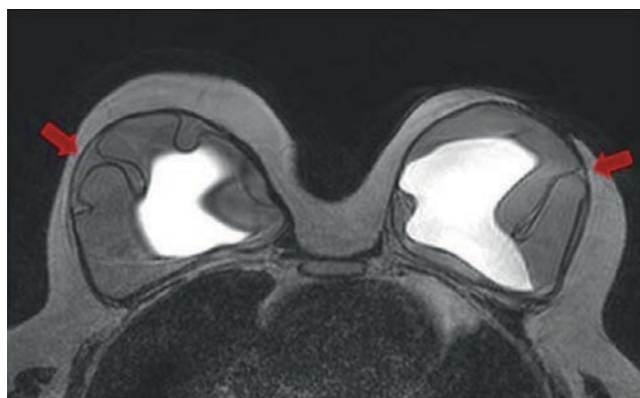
Patient with bilateral mastectomy with heterologous reconstruction involving double-lumen expanders with definitive intention. Breast MRI (T2 sequence, axial plane): Both chambers can be seen in both breasts. The inner chamber is white because it consists of saline solution, and the outer one is gray because it consists of silicone gel. A subcapsular line (red arrow) is seen beside both outer chambers with silicone signal on both sides of the line indicating bilateral intracapsular rupture
